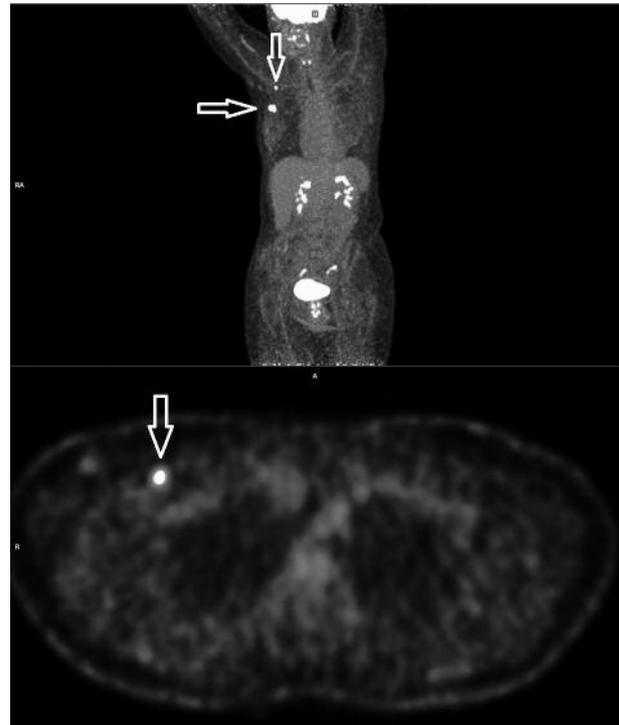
Whole-body (A) and transverse (B) images of positron-emission computed tomography using  $^{18}\text{F}$ -fluorodeoxyglucose. Triple-negative invasive ductal carcinoma (grade 3), exhibiting extreme  $^{18}\text{F}$ -fluorodeoxyglucose accumulation in the primary site (horizontal arrow), and in axillary level II metastases (vertical arrows).
